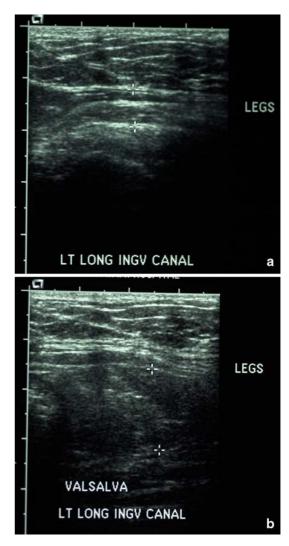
Inguinal ultrasound at rest and with Valsalva.Note separation of external oblique and floor with Valsalva
